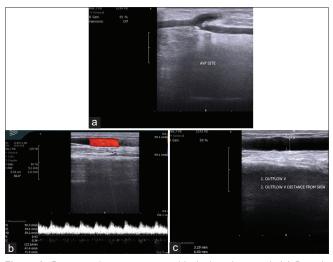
Postoperative assessment with duplex ultrasound. (a) B-mode scan showing AV fistula site. (b) Measurement of blood flow through AV fistula. (c) Measurement of outflow vein diameter and its distance from the skin. AV = Arteriovenous
